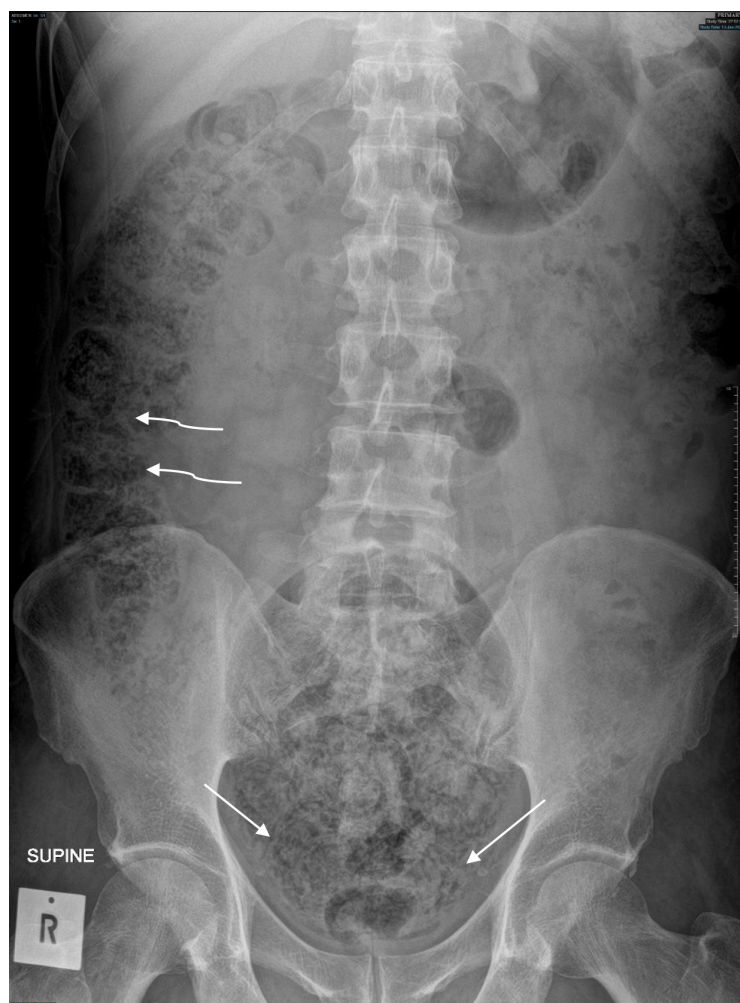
Supine abdominal radiograph. It showed faecal loaded appearance at the pelvic region (arrow) similar to faecal loaded seen along the ascending colon (curve arrow).*
